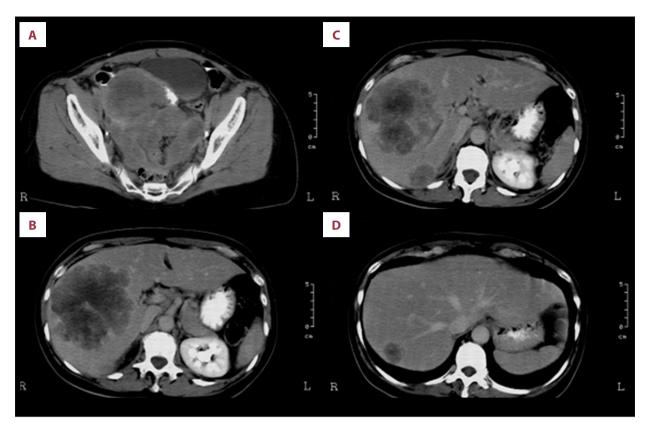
Computed tomography scan from Case 1 at diagnosis. (A) The pelvic tumor. (B–D) The extensive metastatic lesions in the liver.
